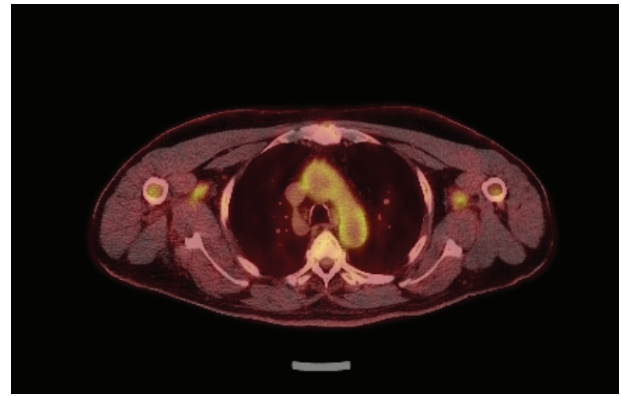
CT-PET image showing increased uptake of tracer (fluorine-18 (F-18) fluorodeoxyglucose (FDG)) in the aortic arch of patient one.
